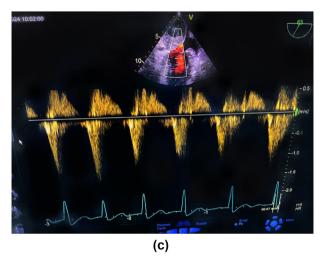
(a) Preoperative computed tomography showing a large left atrial mass occupying whole of atrium. (b) Preoperative transoesophageal
